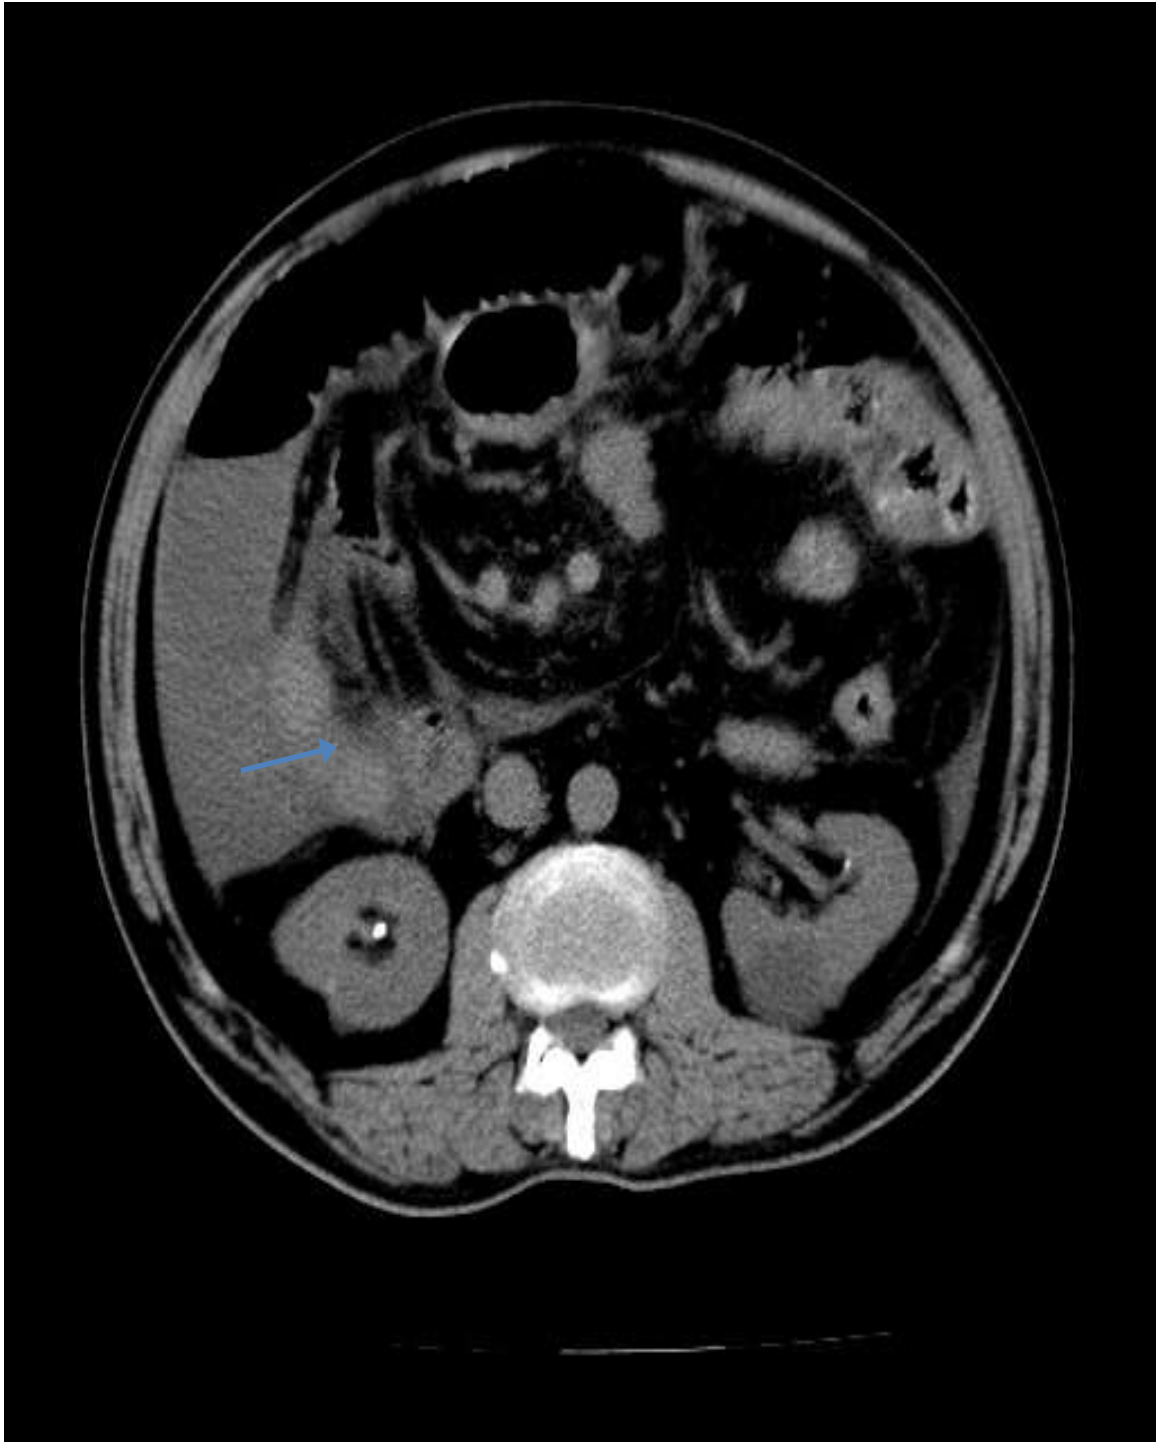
Non Contrast axial CT shows Rt renal calculus - arrow
